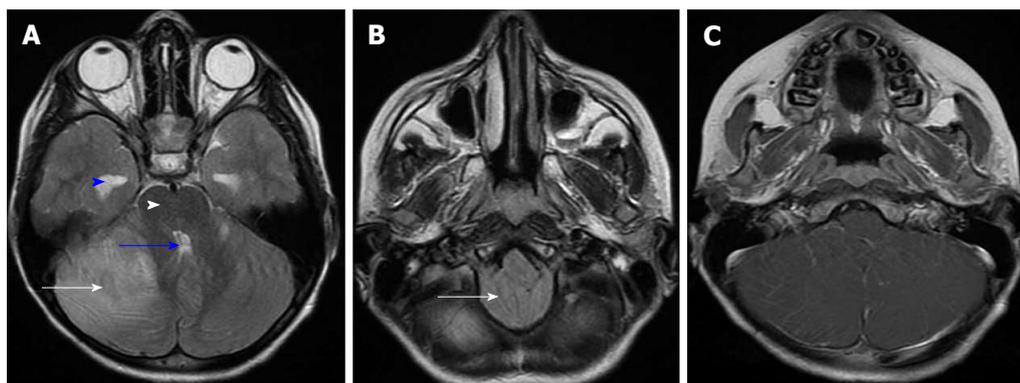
Magnetic resonance imaging: T2 and T1 post contrast images. A and B: Cerebellar hyperintense areas on T2-weighted images predominant on the right side (white arrow in A), related to diffuse edema and producing cerebellar mass-effect on the fourth ventricle (blue arrow) and brainstem (white head arrow), tonsillar herniation (white arrow in B) and supratentorial hydrocephalus (blue head arrow); C: Gadolinium-enhanced T1-weighted sequence revealed leptomeningeal enhancement along the cerebellar folia.
